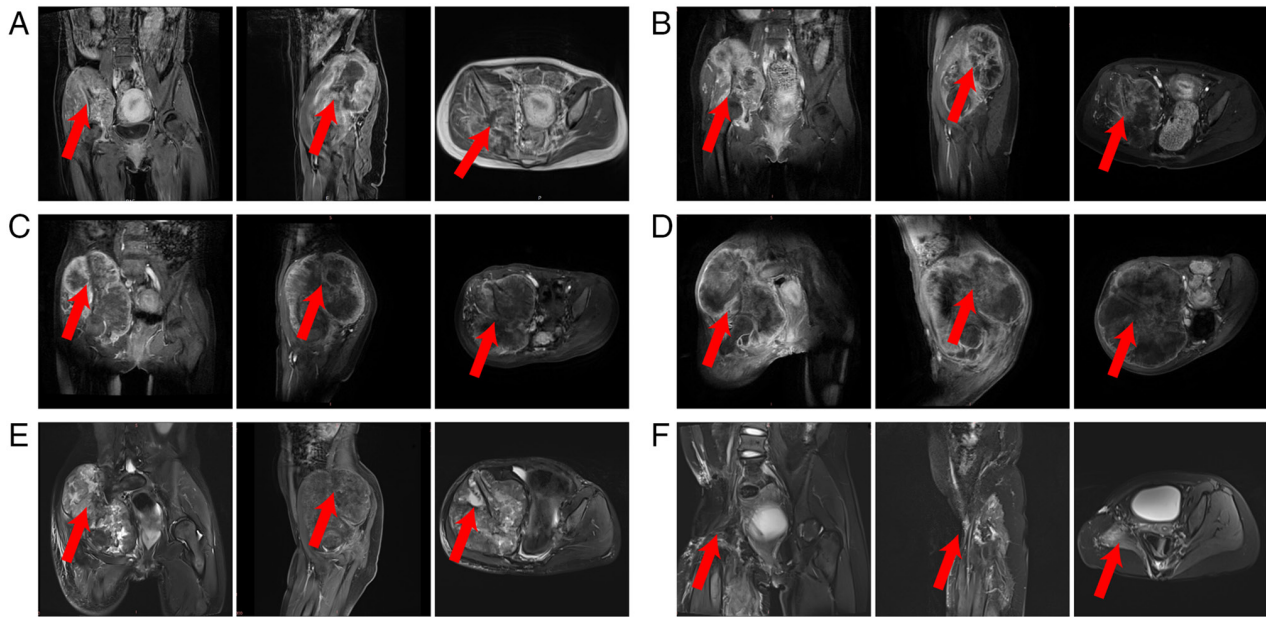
MRI images. The left panel shows a coronal view, the middle panel shows a sagittal view and the right panel shows an axial view of the pelvis. The red arrows point to the primary malignant lesion of the right iliac bone. (A) Before treatment, pelvic MRI (performed in September 2021) showed a lesion of the right iliac bone, the tumor size was ~116x90x125 mm, the lesion involved the right ilium, acetabulum and sacral vertebrae, showing osteolytic bone destruction, and multiple soft tissue masses were formed around. (B) After 2 cycles of chemotherapy with MIAP (high-dose methotrexate, ifosfamide, cisplatin combined with liposomal doxorubicin), pelvic MRI performed in March 2022 showed that although the mass was not significantly small, the central necrosis increased significantly. (C) The mass enlarged after the treatment was interrupted, as revealed by MRI performed in August 2022, due to the spread of the COVID-19 pandemic. (D) After chemotherapy and radiotherapy, the pelvic lesions were significantly enlarged. (E) Pelvic MRI performed in May 2023 showed that, after gemcitabine combined with docetaxel or nab-paclitaxel chemotherapy combined with immunotherapy and targeted therapy, the patient's lesions were stable and ready for surgery. (F) There was no tumor recurrence after surgery, as indicated by pelvic MRI performed in April 2024.
